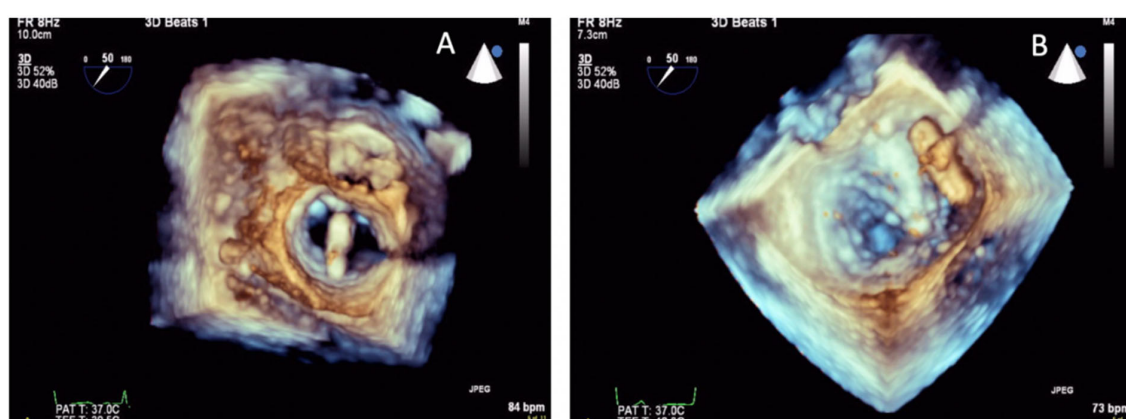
Real-time 3D transesophageal echo (RT 3D TEE) to guide placement of the MitraClip device by lining the device perpendicular to the line of coaptation (A); RT 3D TEE to guide placement of the second MitraClip device (B)
